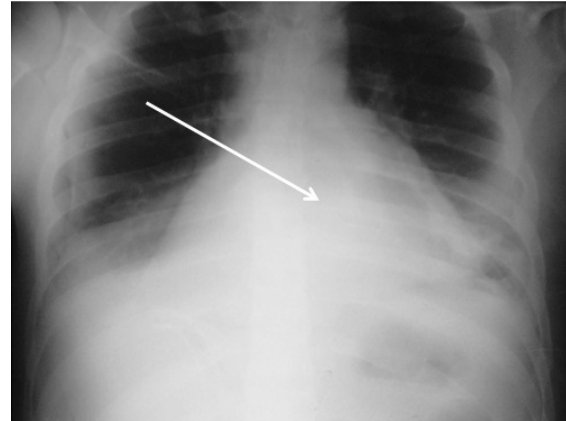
X-ray of the chest. Arrow shows large cardiac shadow as a result of pericardial effusion
